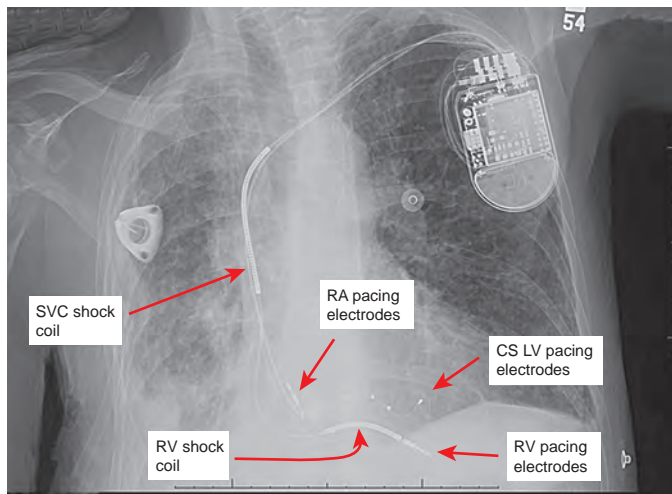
Defibrillator system with biventricular (BiV) antibradycardia pacemaker capability. Note that three leads are placed: a conventional, bipolar lead to the right atrium; a true bipolar right ventricular (RV) lead with shock coils in the right ventricle and the superior vena cava (SVC), and a quadripolar lead to the coronary sinus (CS). This system is designed to provide “resynchronization (antibradycardia) therapy” in the setting of a dilated cardiomyopathy with a prolonged QRS complex (and frequently with a prolonged P-R interval as well). The bipolar lead in the right atrium will perform both sensing and pacing function. The true bipolar (discrete tip and ring) electrodes in the right ventricle provide pacing and sensing function. The presence of a “shock” conductor (termed *shock coil*) on the RV lead in the right ventricle distinguishes a defibrillation system from a conventional pacemaking system. The lead in the CS depolarizes the left ventricle, and this particular catheter has four electrodes in the CS to allow optimization of left ventricular (LV) pacing (a close-up of the St. Jude generator is demonstrated in Fig. 5.4). Because of the typically wide native QRS complex in a left bundle branch pattern, failure to capture the left ventricle can lead to ventricular double-counting (and inappropriate antitachycardia therapy) in a BiV transvenous implantable cardioverter-defibrillator (ICD) system. Many defibrillation systems also have a shock coil in the SVC, which is most often electrically identical to the defibrillator case (called the *can*). When the defibrillation circuit includes the ICD case, it is called *active can configuration*. Incidental findings on this chest radiograph include the presence of a right-sided implanted central venous catheter, right pleural effusion, and scoliosis.
